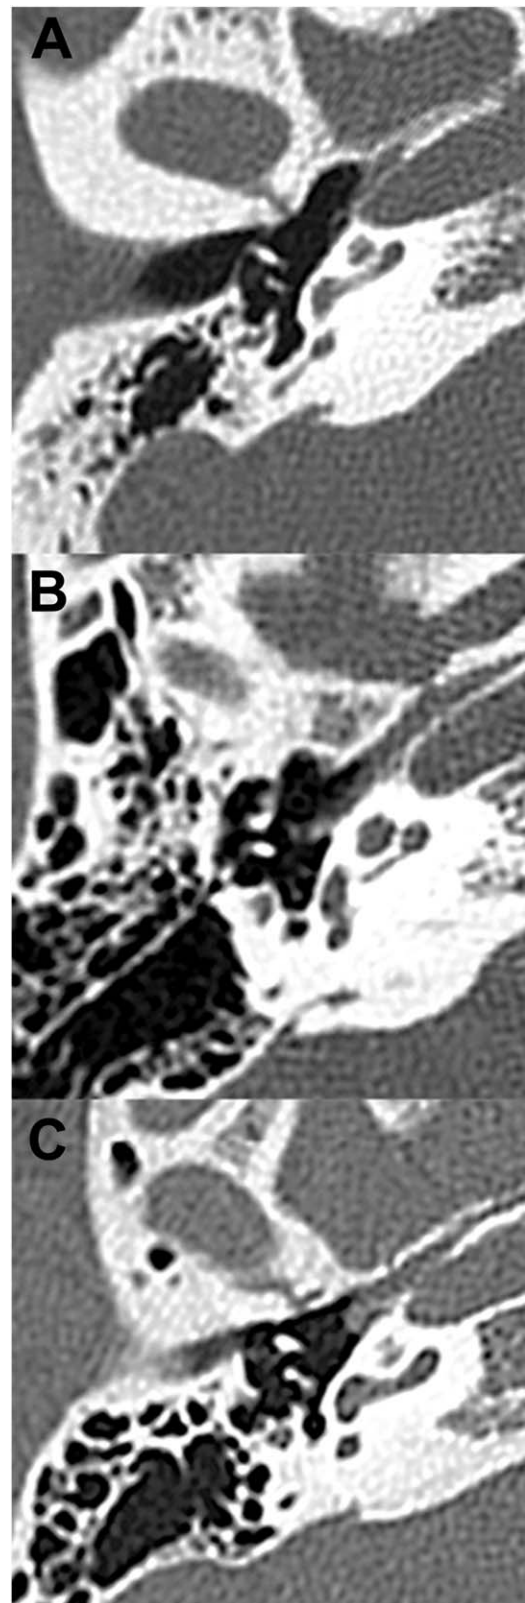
Radiomorphologic evaluation of the depth and extension of the fs in relationship to the mastoid portion of the facial nerve (based on axial computed tomography scan, right ear). (A) Small fs. (B) Deep fs with posterior extension. (C) Very deep fs with medial and posterior extension. Black arrow indicates the third portion of the facial nerve. fs = facial sinus.
